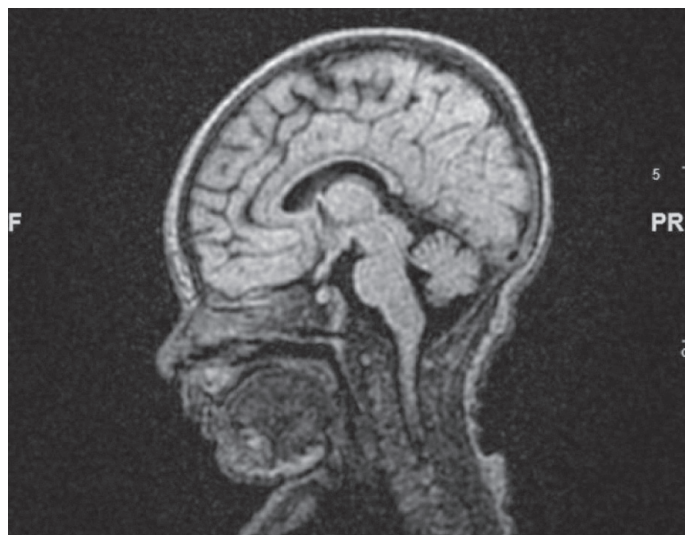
MRI brain showing normal posterior fossa ruling out Dandy Walker Malformation
